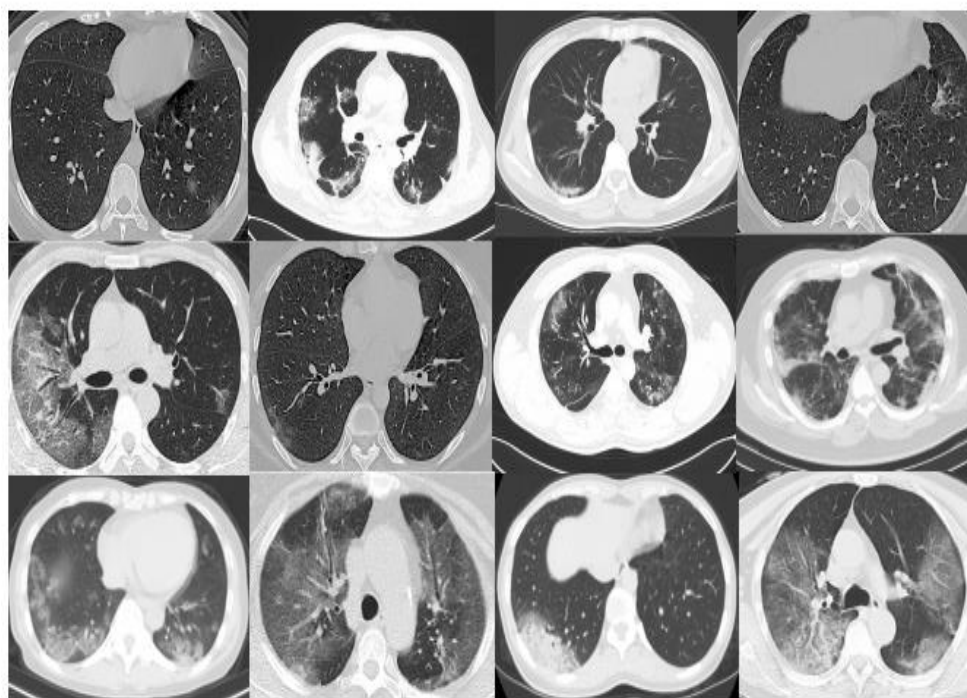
Example of an image in the COVID-19 CT dataset.
